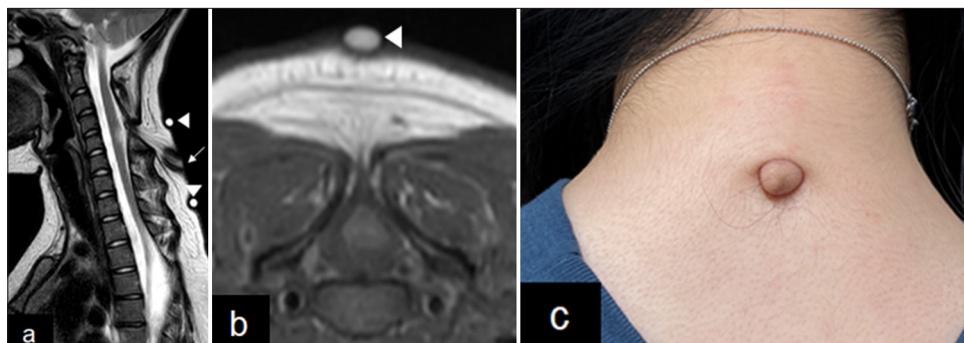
Neuroradiological and photo-imaging of skin lesion. (a) Mid-sagittal T2-weighted MRI of cervical spine at age 18. The arrow indicated skin lesions, and arrowheads were landmarks of the skin lesion at the time of MRI examination. (b) Axial T2-weighted MRI at C5. The spinal cord is tethered posteriorly to the tract. The arrowheads are landmarks of the skin lesion at the time of MRI examination. (c) Photograph showing a wart-like cutaneous appendage over the nape of the patient's neck. MRI: Magnetic resonance imaging.
